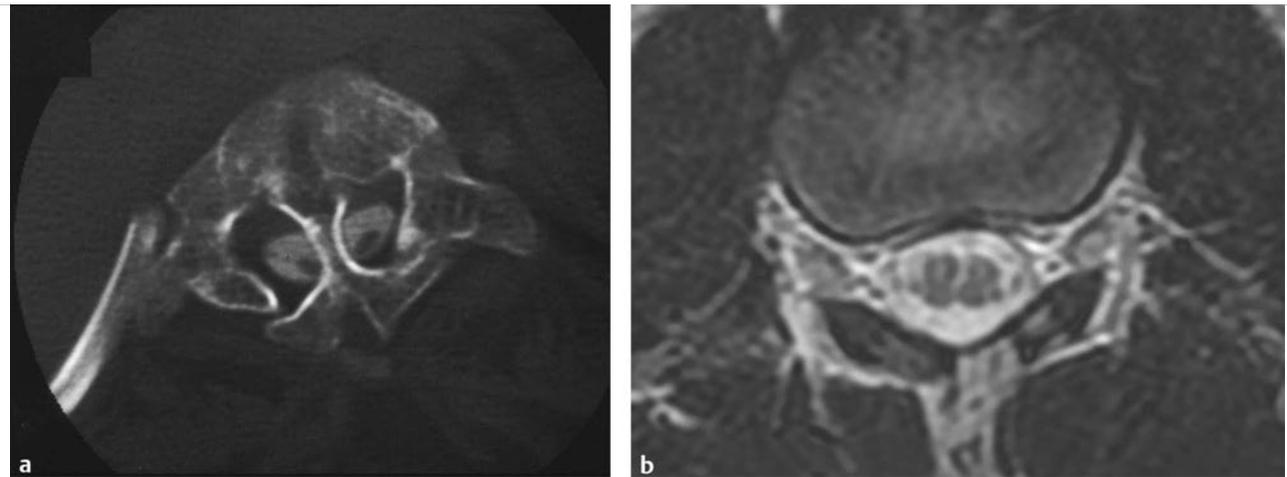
(a) Computed tomographic myelogram of the upper lumbar spine. Dysmorphic bone is applied over the dorsal surface of the cord. A bony septum with a dural sleeve penetrates the split on this and adjacent images. (b) Axial magnetic resonance image of a type 2 split-cord malformation. The patient's symptoms were caused by tethering bands arising from the medial aspect of each hemicord and fixing the cord dorsally. The bands are not visualized on this study.
